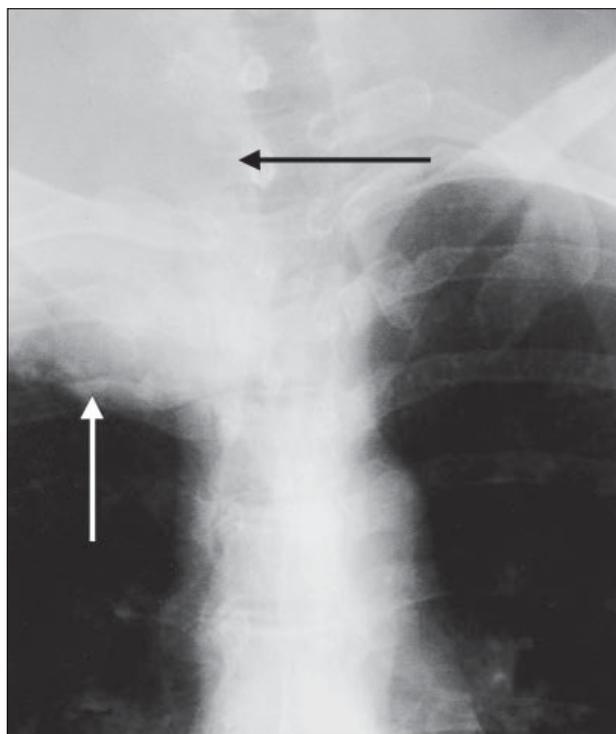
Frontal radiograph of the thoracic spine demonstrates a large soft tissue mass at the right lung apex (white arrow), with destruction of the right T1 transverse process, and right first rib posteriorly (black arrow), suggestive of a Pancoast tumour.
